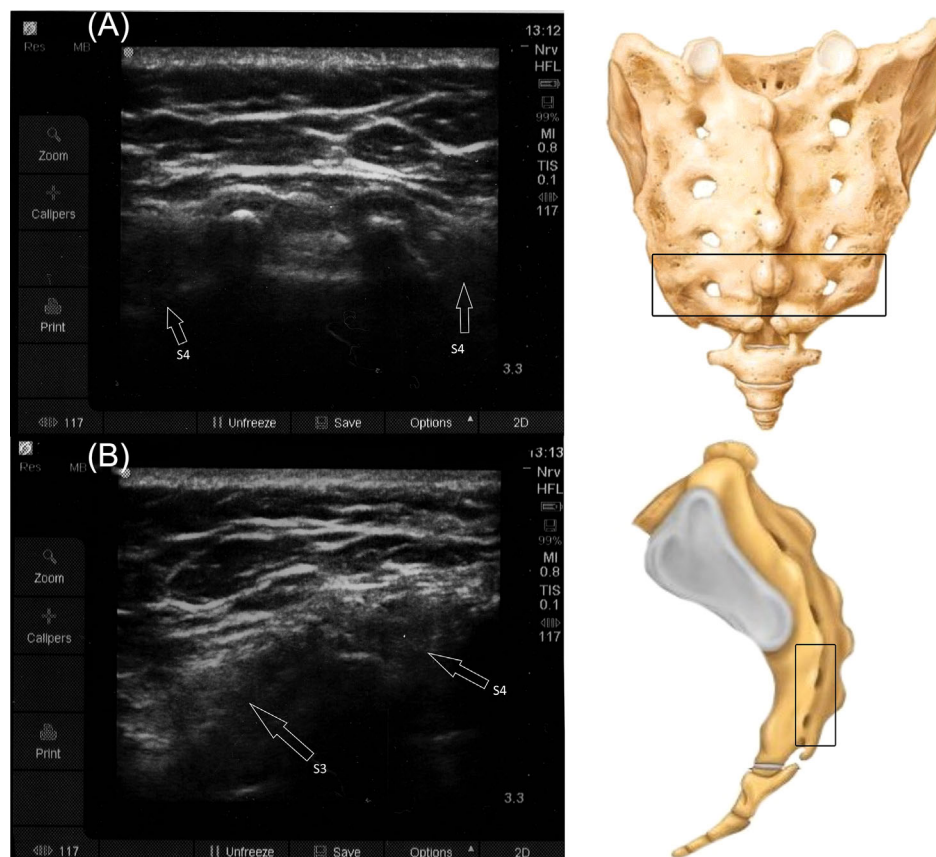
Ultrasound view in the transverse plane identifying S4 foramina (A). Once this landmark has been identified, the probe is shifted laterally, toward the desired testing site and turned in the sagittal plane to identify the S3 foramen (B)
